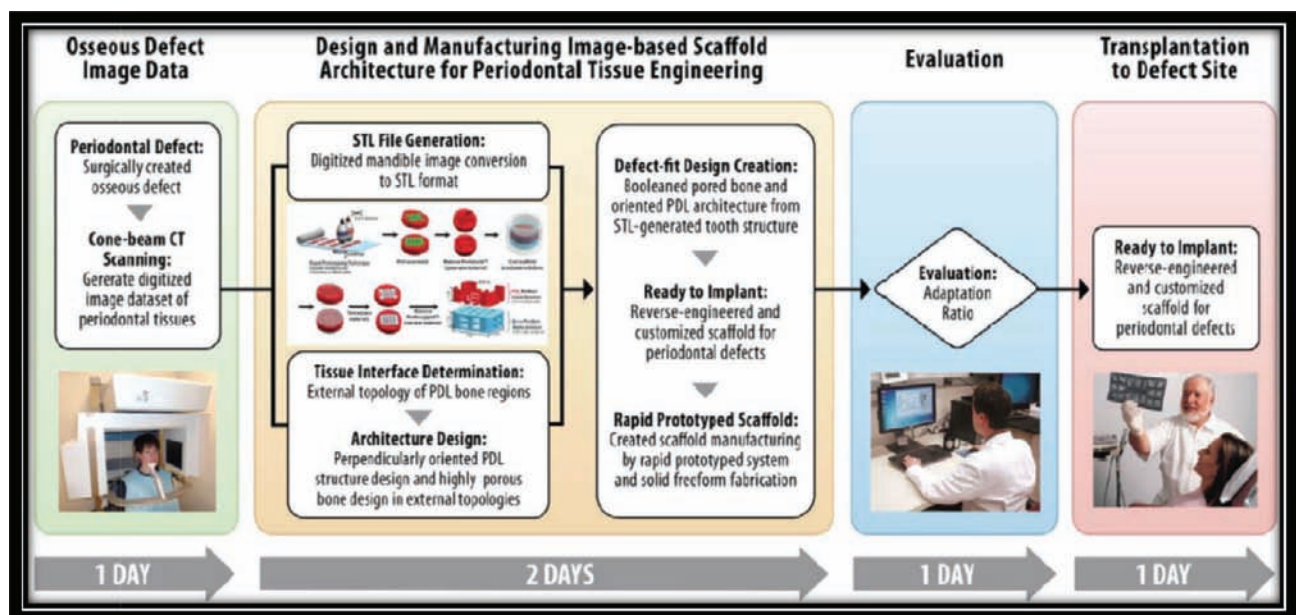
CAD models are produced based on computed tomography (CT) scans of a patient-specific bone defect to develop a custom-made bone graft substitute. Courtesy of Park et al., 2014
